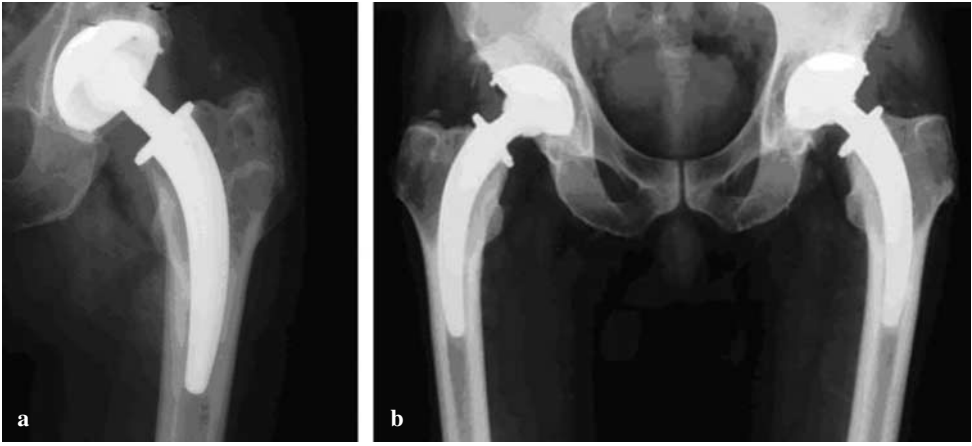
Bone resorption at the prosthetic rim in the lateral and medial parts of the femoral neck, resembling a rounded-off spur, seen at the 6-month follow-up. In this patient, the stem is slightly oversized. The fact that the rim was not resting properly was apparent even at the immediate postoperative radiograph
